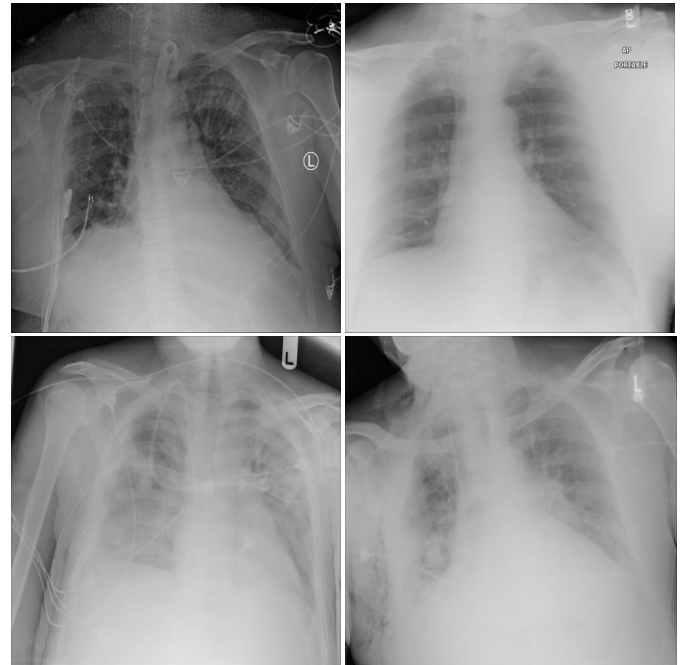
Several X-ray images from the CVC Dataset [29].
